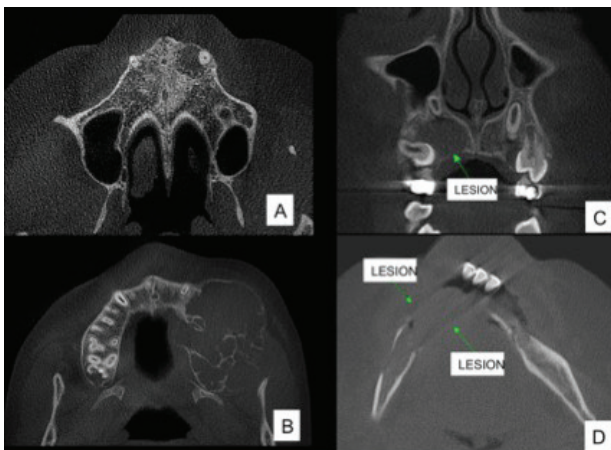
CBCT axial cuts of maxilla evidencing: (A) lesion of unilocular aspect; (B) lesion of multilocular aspect. Coronal cut (C) evidencing a well-defined lesion. Axial cut showing a lesion with poorly defined limits (imprecise).
